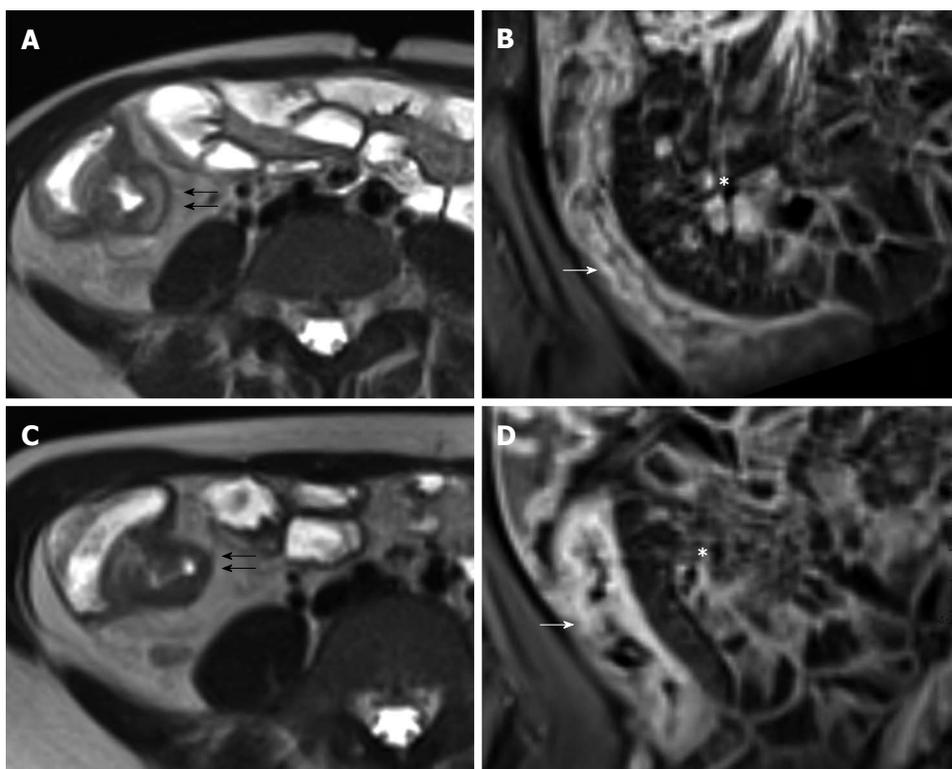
Twelve years old female with active disease and follow-up. Transverse T2-weighted image (A) shows mural thickening (arrows) and increased mural signal (arrow) in the terminal ileum and coronal T1-weighted image (B) shows mural stratification (arrow), increased mesenteric vascularity adjacent to the inflamed bowel loop (the comb sign), and enlargement and hyper-enhancement of lymph-nodes (asterisk). In the same patient and at the same level, six months later after therapy, transverse T2-weighted image (C) shows the loss of increased mural signal (arrow) and coronal T1-weighted image (D) shows homogeneous enhancement without mural stratification (arrow), reduction of increased mesenteric vascularity adjacent to the inflamed bowel loop, and disappearance of lymph-nodes (asterisk).
